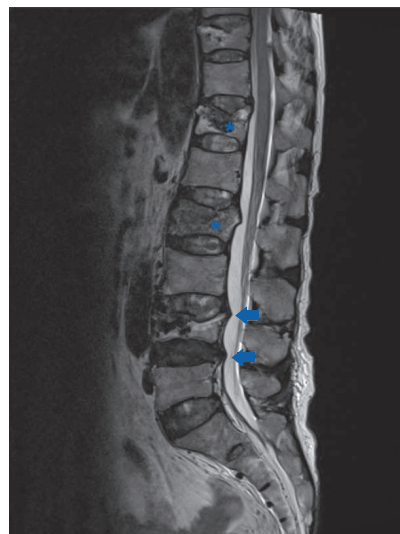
Post-operative L-spine MRI. Asterisks indicate T12 and L2 compression fracture. Arrow indicates L3-4, 4-5 mild disc space bulging.
